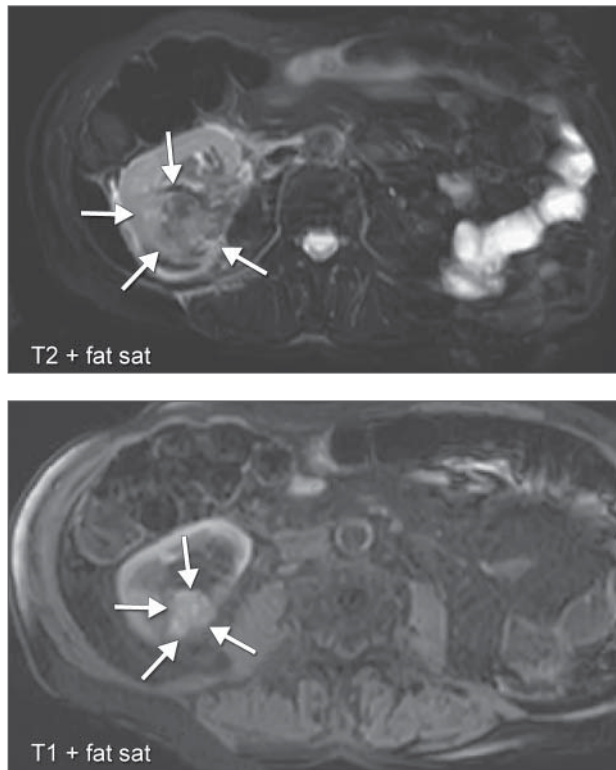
A: MRI before RFA showing the renal tumor (arrows). B: Postinterventional control MRI 2 days after RFA, already showing shrinkage of the tumor (arrows).
